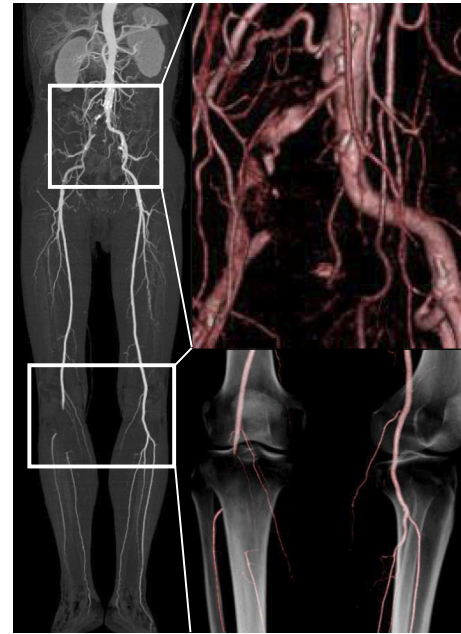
Contrast-enhanced computed tomography angiogram at the onset of thromboembolic events showed narrowing of the right common iliac artery and complete occlusion of the right popliteal artery. Enlarged images of the common iliac artery and the right popliteal artery are shown in the boxes.
